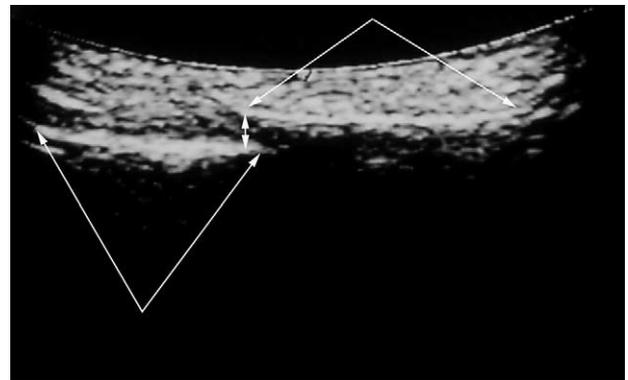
Ultrasound image of a fracture of the lateral orbital wall. The double arrow shows the position of the dislocation. The upper and lower arrows show the lateral orbital wall.
